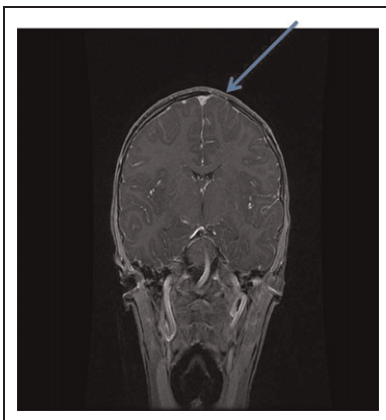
MRI of the brain showing the presence of a well-defined osseous defect consistent with a parietal foramina.
